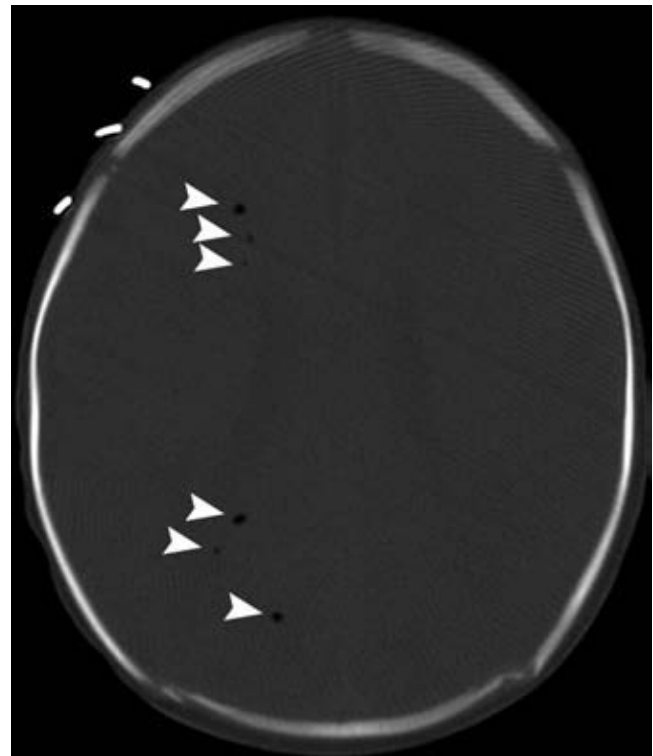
Air embolization on CT. A pediatric head CT scan for altered neurologic status following a noncerebral diagnostic study shows substantial air embolization within the brain parenchymal (*arrowheads*). It is possible that very small quantities of gaseous microemboli are commonplace during angiographic injections and may be tolerated by cerebral circulation (see text), but the level of embolic gas seen in this patient was undoubtedly excessive and correlated with the clinical deterioration of the patient. The observation that gaseous microemboli might be universal on TCD studies performed during cerebral angiography should not permit one to become complacent about the dangers of macroscopically visible air in lines or syringes.
